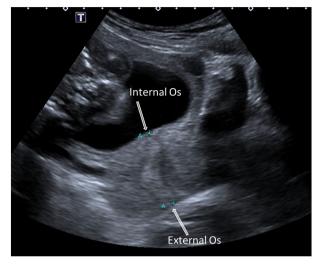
Transabdominal ultrasound cervical length with an empty bladder.
